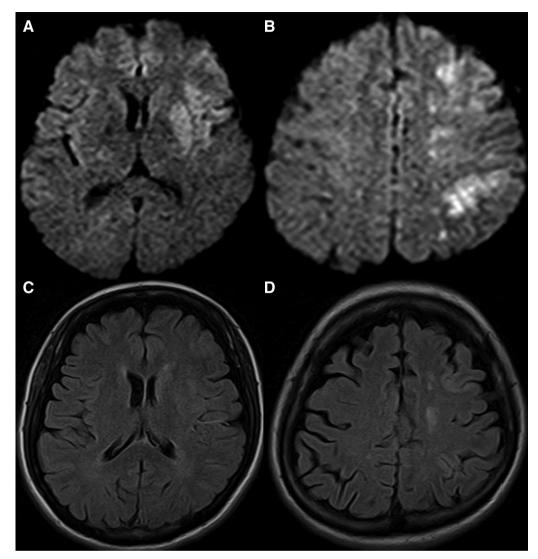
DWI MRI showed multiple hyper-intensity lesions (A and B). MRI FLAIR did not show as extensive hyper-intensity lesions as DWIs (C and D). DWI/FLAIR mismatch was determined. DWI: diffusion-weighed imaging; MRI: magnetic resonance imaging
